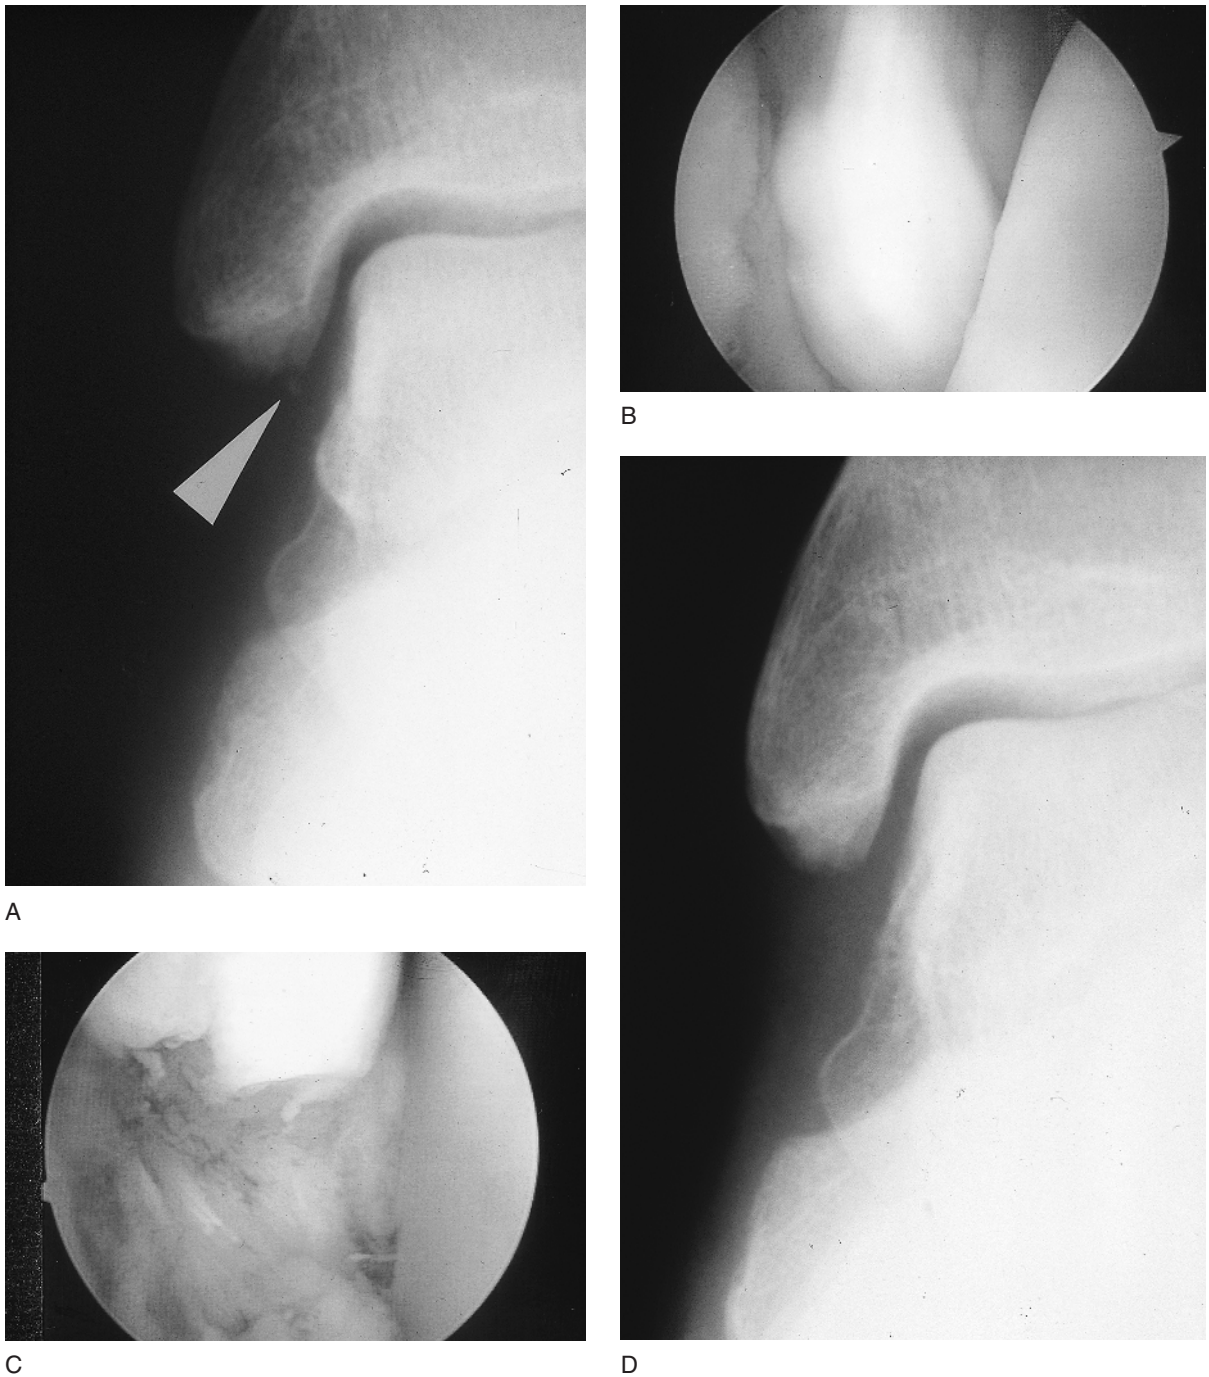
This patient had a 6-month history of persistent pain following a “severe ankle sprain.” A: AP radiograph demonstrating a small avulsion fracture of the distal medial malleolus. B: Arthroscopic view of the medial gutter revealing fibrous nonunion of the avulsion fracture. C: View of the medial gutter after arthroscopic excision of the fibrous nonunion. D: Postoperative AP radiograph after excision of the avulsion nonunion. The patient experienced complete relief of symptoms within 8 weeks after operation.
